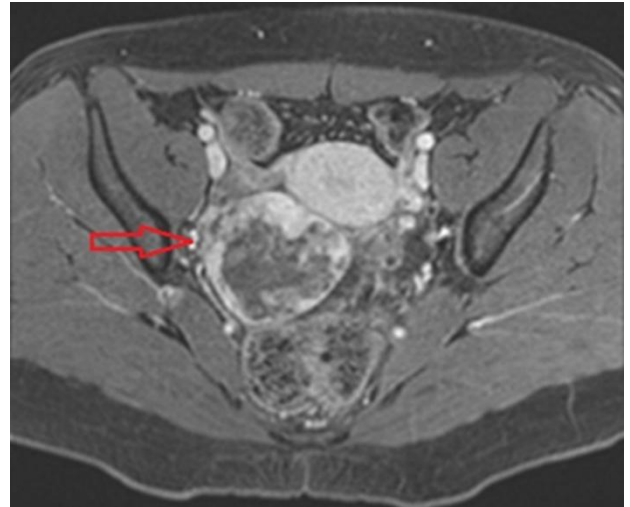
Pre-operative MRI showing the mass located at the right adnexial area (red arrow).
